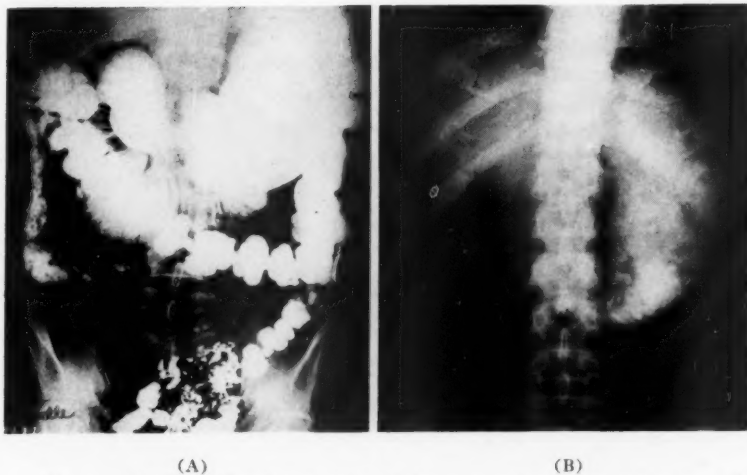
(A) Note dilatation of entire duodenum secondary to obstruction near the ligament of Treitz. (B) Plain film of abdomen one week after barium meal, showing barium still present, indicating the completeness of the obstruction.
